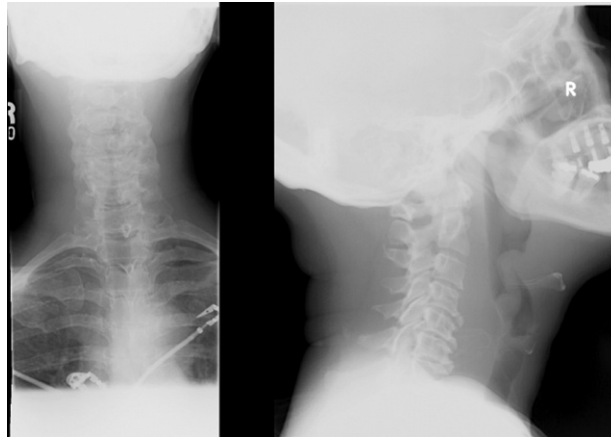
Anterior-posterior and lateral soft tissue radiograph of the neck.
